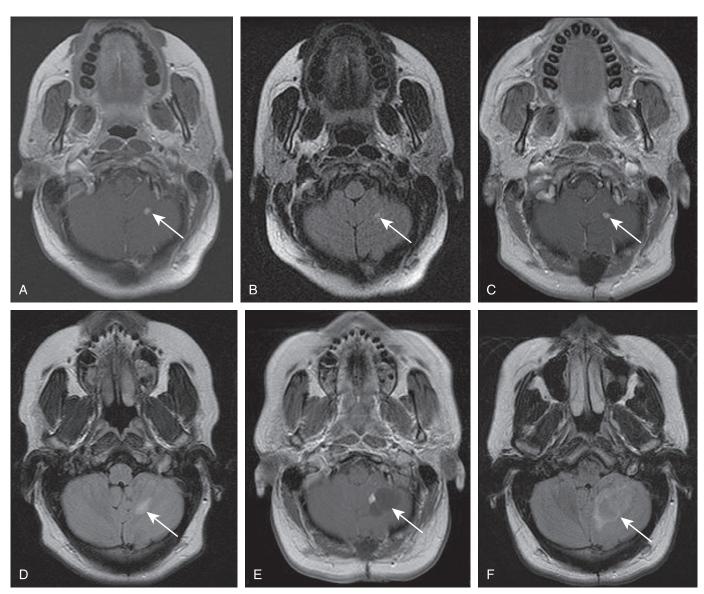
Evolution of hemangioblastoma. Axial T1 postcontrast (A) and fluid-attenuated inversion recovery (FLAIR)-weighted (B) images demonstrate an enhancing nodule (arrow in A) without associated edema (arrow in B). Axial T1 postcontrast (C) and FLAIR-weighted (D) images at 1 year follow-up demonstrate a stable enhancing nodule (arrow in C) with interval development of surrounding edema (arrow in D). Axial T1 postcontrast (E) and FLAIR-weighted (F) images at 3-year follow-up demonstrate a slight interval increase in the nodule size, interval development of a cyst (arrow in E), and increased surrounding edema (arrow in F).
